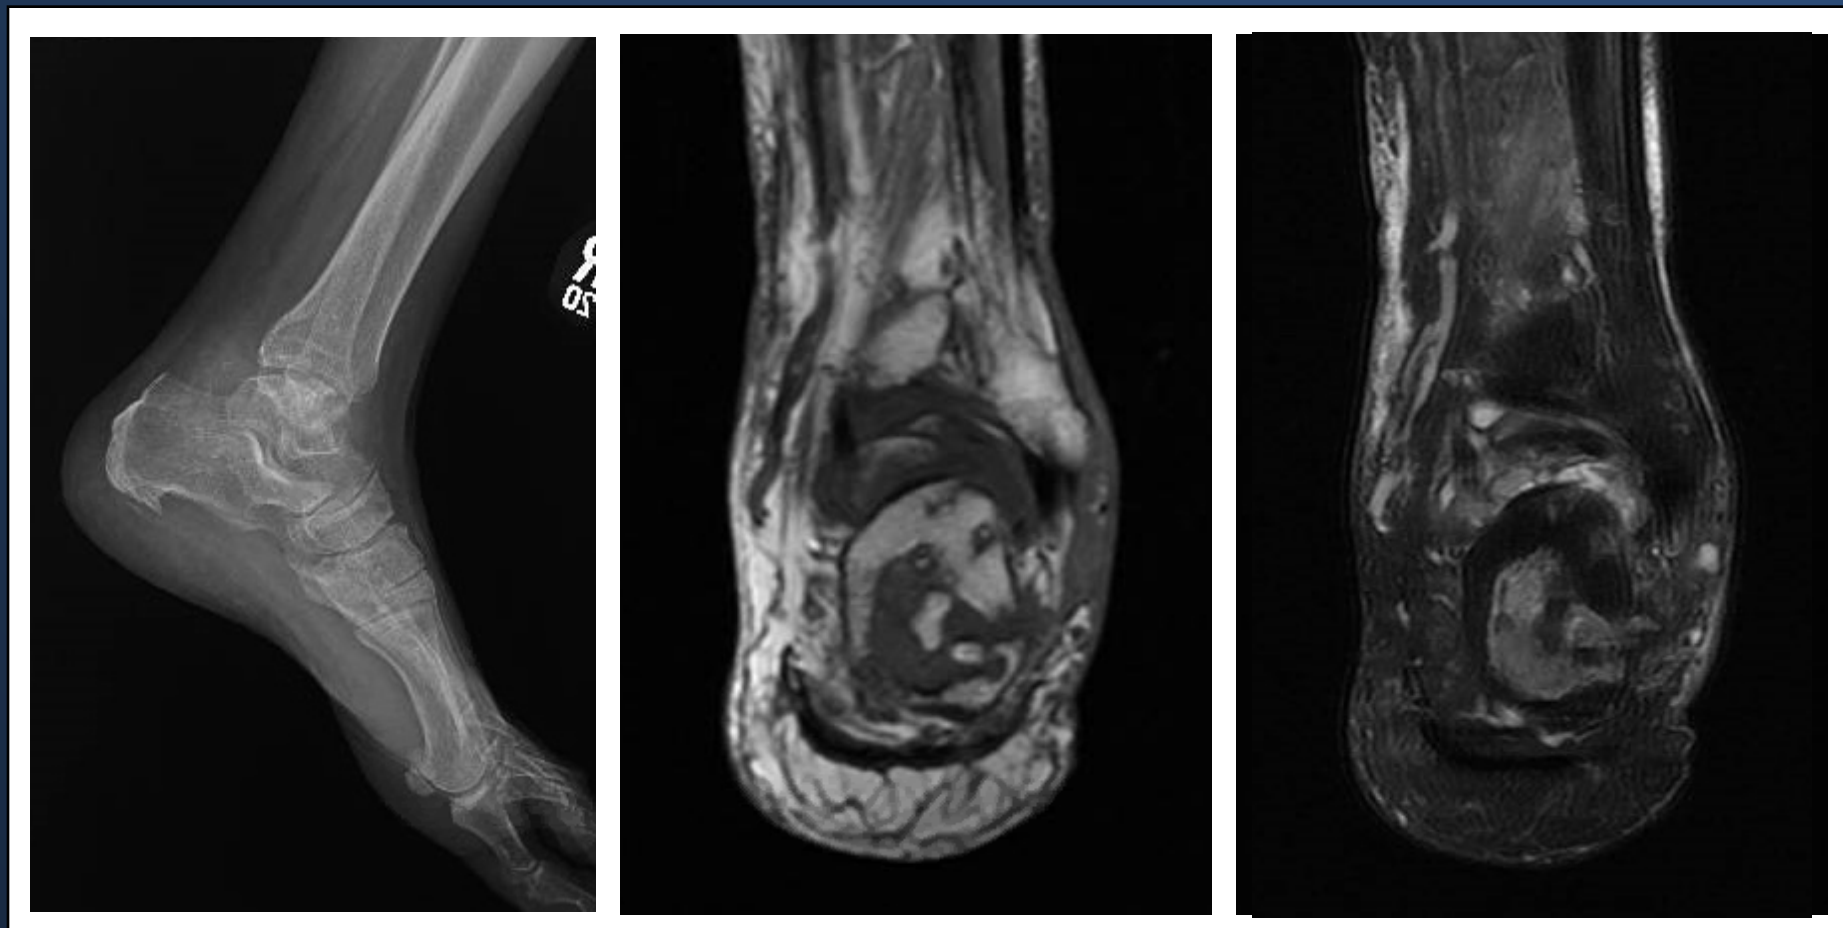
Pre-op x-ray Figure 2A, 2B: Initial T1 and STIR images
